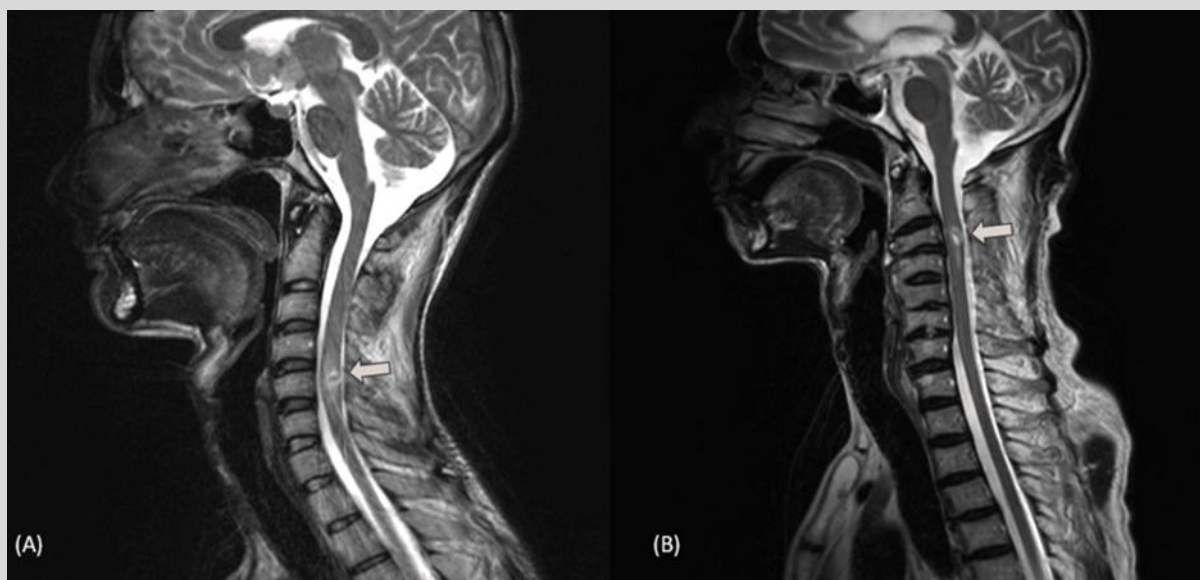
Magnetic resonance images demonstrating subaxial cervical spine instability with spinal cord compression.
